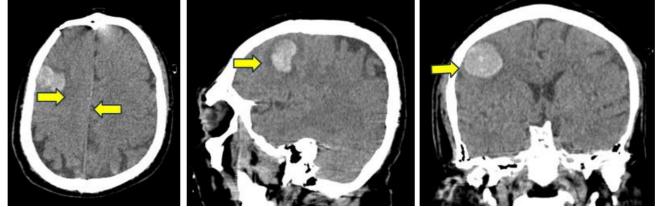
Plain CT brain shows, two fairly well-defined rounded closely opposed hyper densities in the right frontal lobe with hemorrhagic changes and perilesional edema (*yellow arrows*) causing mass effect in the form of effacement of adjacent sulci
